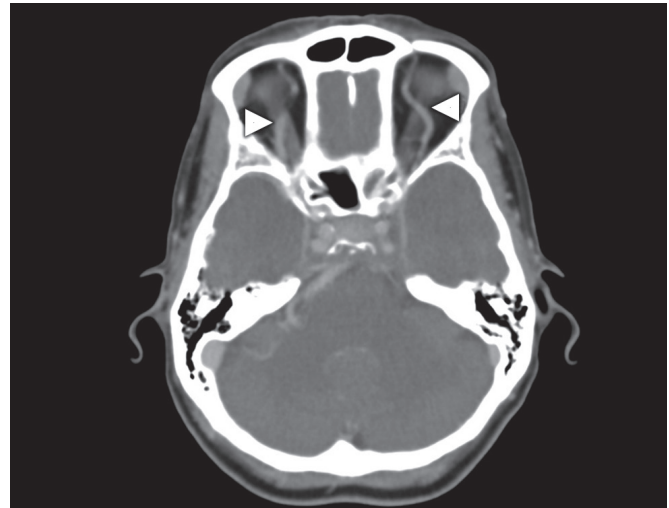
Axial CT venogram. Both superior orbital veins (arrowheads) are engorged due to cavernous sinus thrombosis. Lack of enhancement of bilateral cavernous sinuses further suggests thrombosis.
